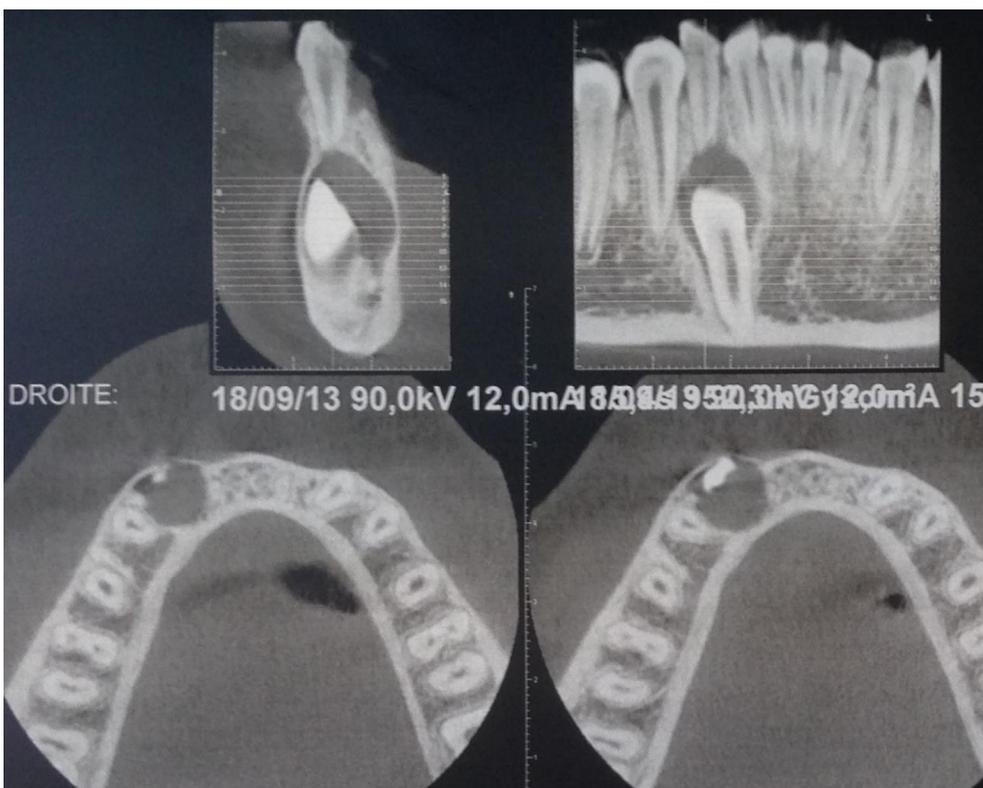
Axial and coronal section of CBCT.
